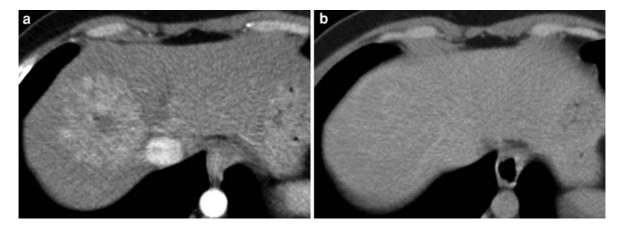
Atypical focal nodular hyperplasia. a Transverse contrast-enhanced CT image during hepatic arterial phase demonstrates a large lesion in the right hepatic lobe, which shows uniform vivid enhancement with the exception of a central scar.
